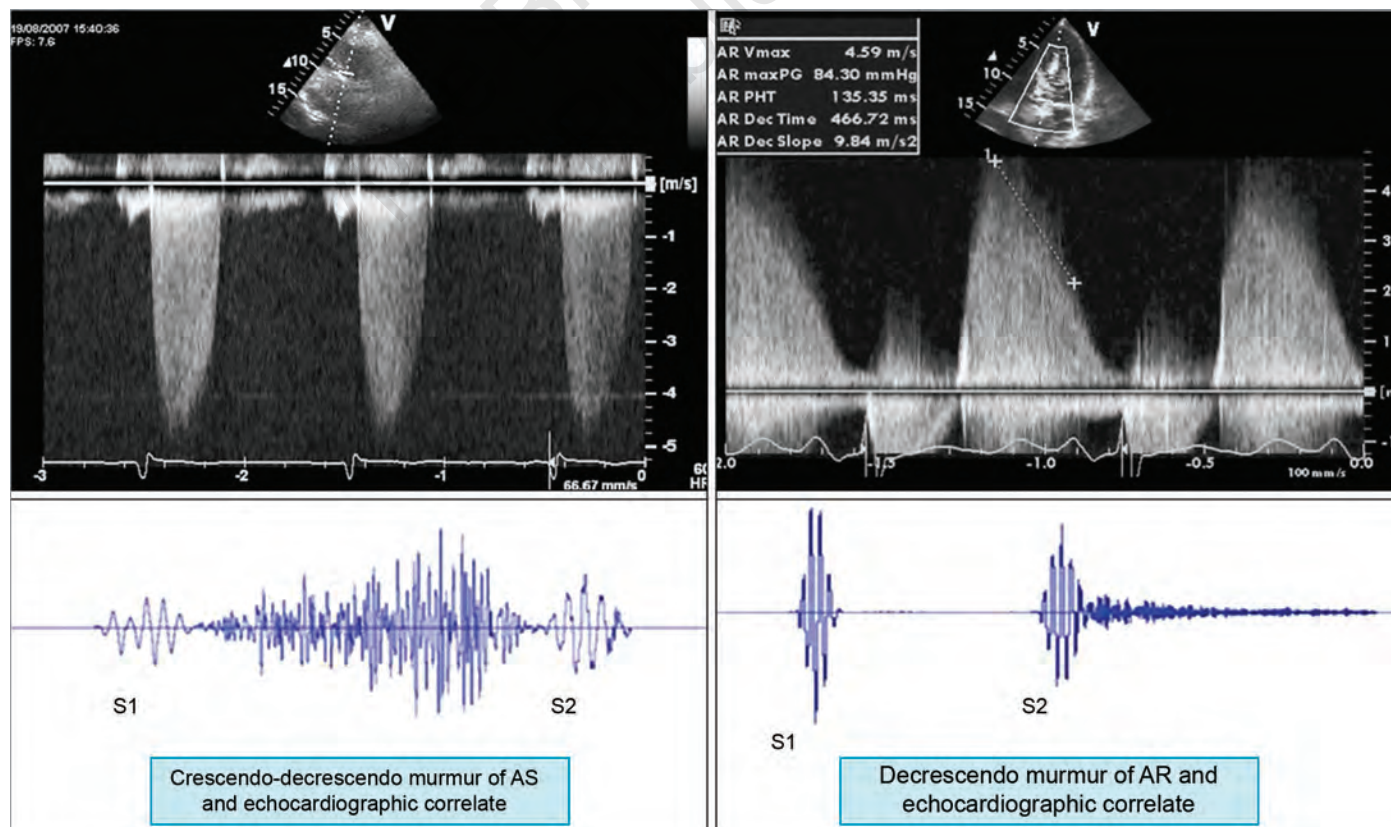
The configuration of aortic stenosis (AS) and aortic regurgitation (AR) murmurs and their echocardiographic correlates.
